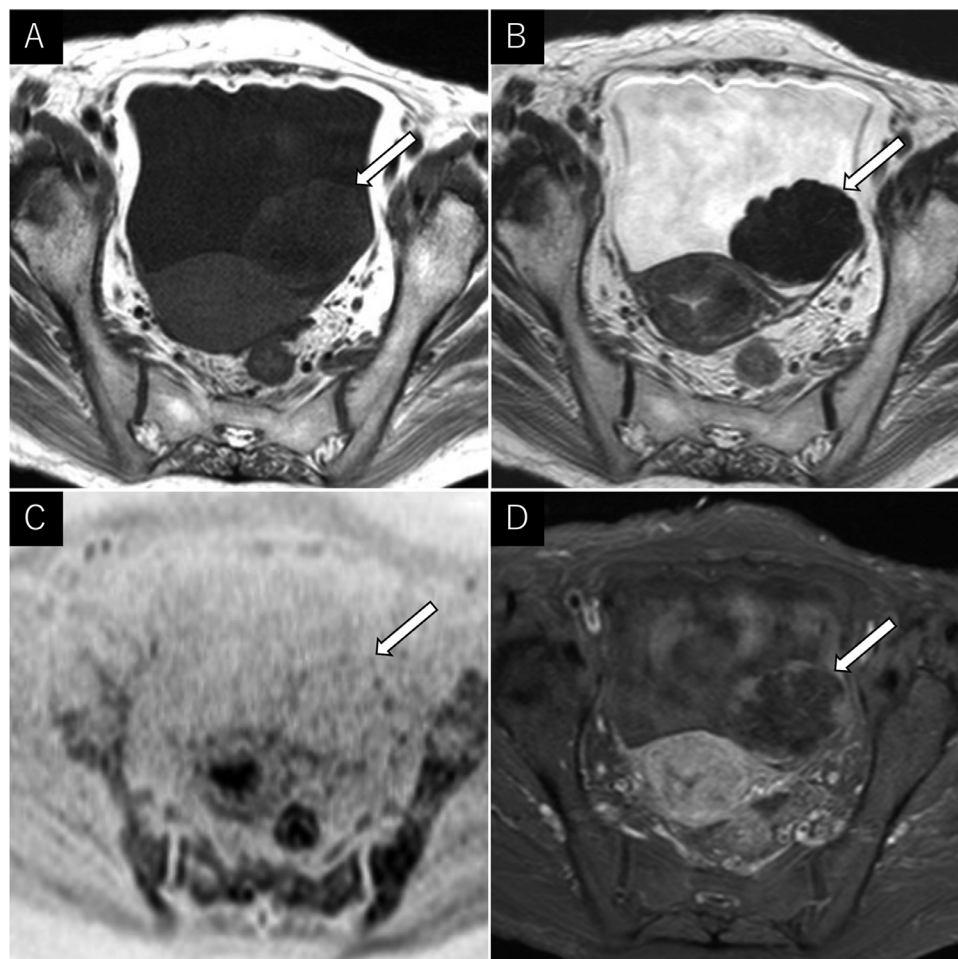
(A, B) The left adnexal tumor is lobulated, exhibiting markedly low signal intensity on T1- and T2-weighted images (arrows). (C) The tumor shows no restricted diffusion on black-and-white inverted diffusion-weighted imaging (arrow). (D) In the late phase of fat-saturated contrast-enhanced T1-weighted images, only the tumor margins exhibit a slightly inferior enhancement than that of the myometrium (arrow).
